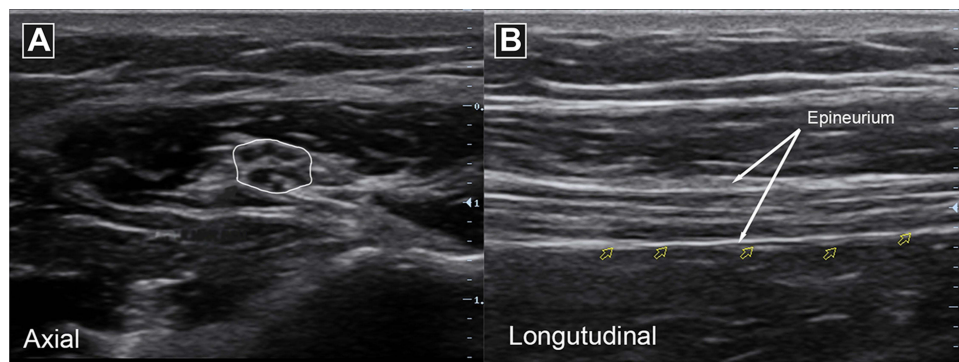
Ultrasound appearance of normal nerves. Ulnar nerve imaged in axial/cross-sectional view with “honeycomb” pattern (A) and longitudinal view with “tram track” pattern (B).
